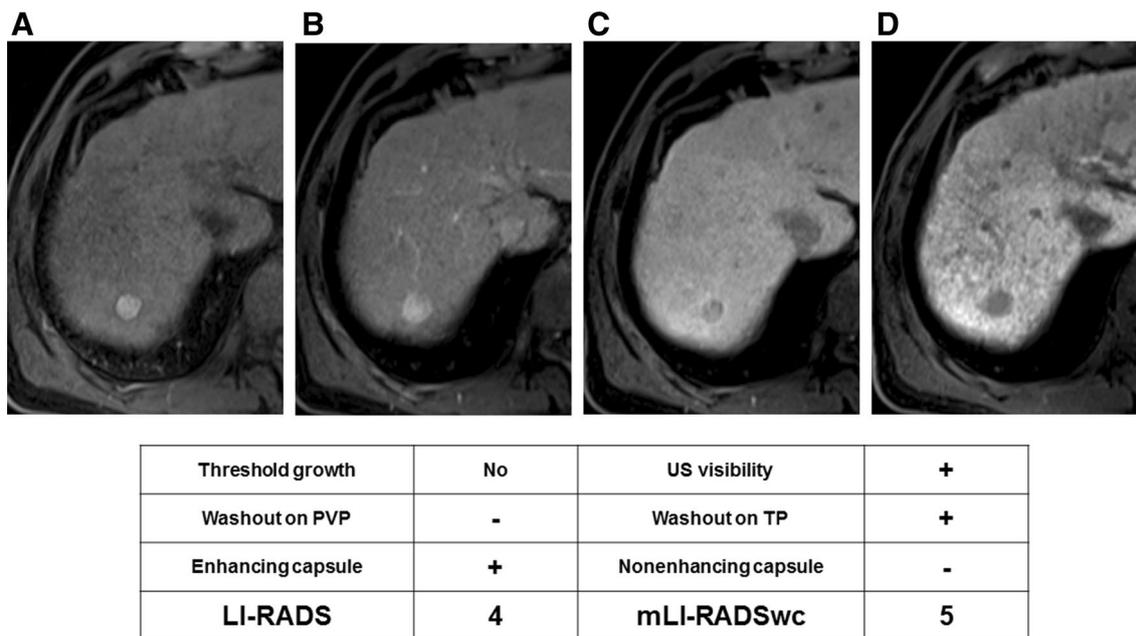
A 1.6-cm clinically benign lesion; Category 4 in the LI-RADS versus category 5 in the mLI-RADSwc. A 66-year-old man with alcoholic liver disease had a nodule at segment 7 of the liver. The lesion was hyperintense compared to the surrounding parenchyma in the pre-contrast T1-weighted image and (a, b) an APHE lesion remained hyperintense with the adjacent parenchyma in the PVP. c, d In the TP and hepatobiliary phase, it was a hypointense lesion. Both observers
